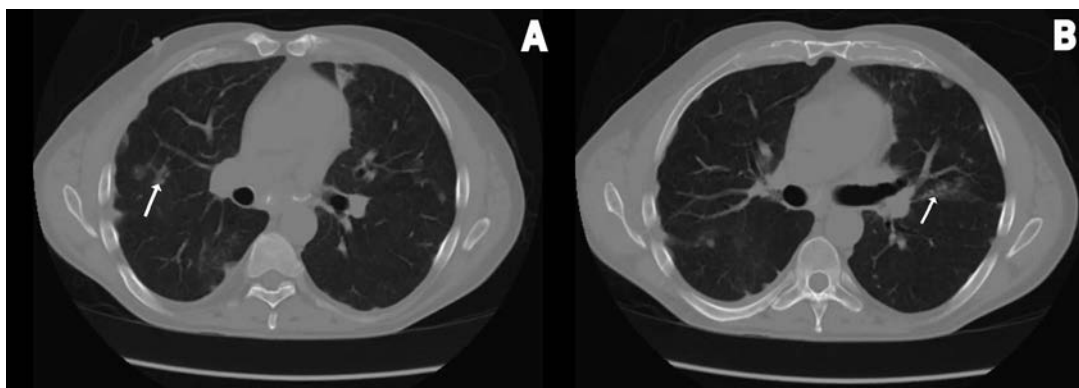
A and B, Bilateral patchy ground-glass opacities and scarring on computed tomography of the chest (arrows).
